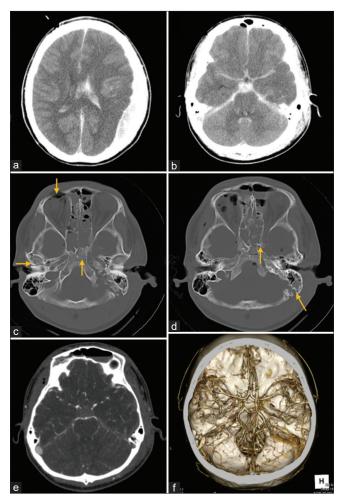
Head computed tomography (CT) shows multiple skull base fractures underlying traumatic subarachnoid hemorrhage and left acute epidural hematoma (a and b). The skull fractures involve the right frontal bone, right pyramidal bone, clivus, left anterior clinoid process, and left mastoid process (c and d; orange arrow). Contrast-enhanced CT of the head shows no obvious aneurysm (e and f).
